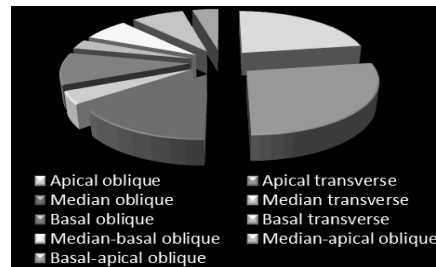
Distribution of chords in position and orientation (according to echocardiography of 29 persons).
